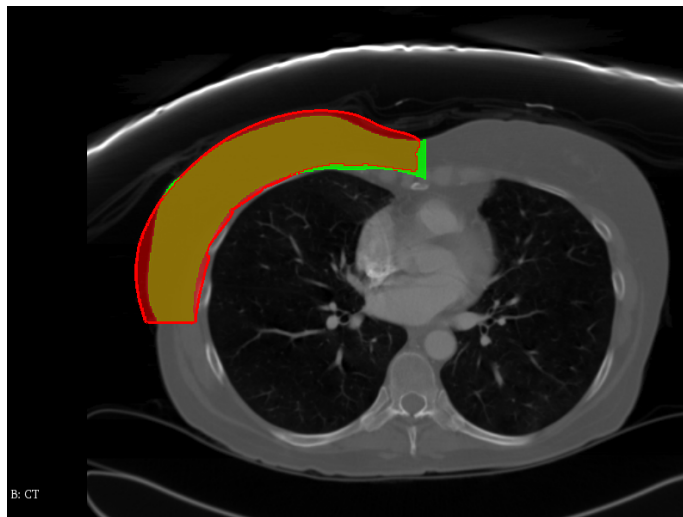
CT image, supine breast mask (green) and deformed mask (red).
